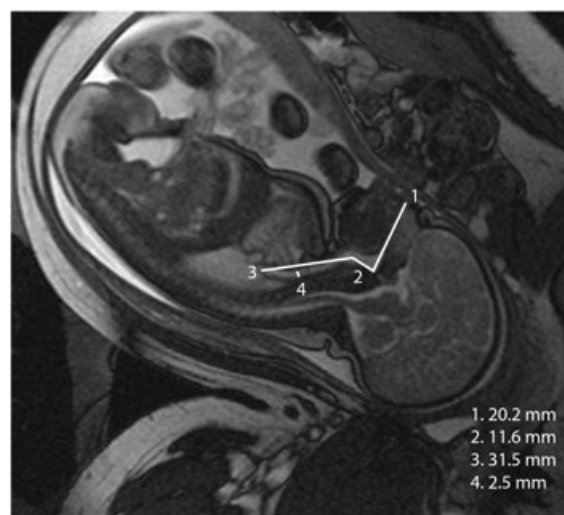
Magnetic resonance imaging of 28-week fetus with airway measurements
